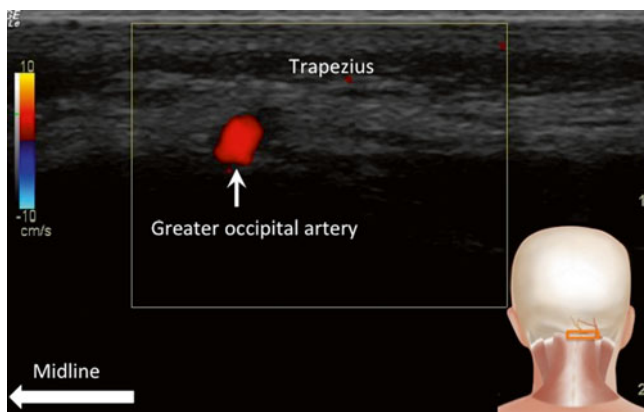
Sonogram of occipital artery just caudal to the superior nuchal line. The artery indicates the plane where the greater occipital nerve lies. The probe position is indicated in the insert lower right corner (Reproduced with permission from Philip Peng Educational Series)
